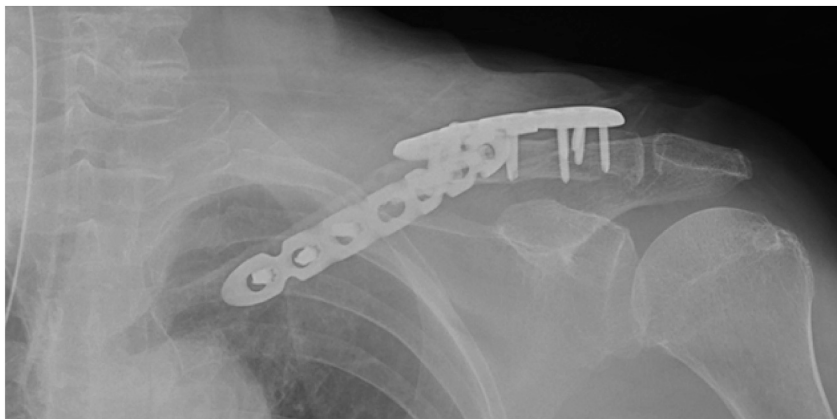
Postoperative X-ray of the bipolar clavicle fracture; the midshaft fracture was fixed with a VA-LCP anterior clavicle plate (DePuy Synthes) and the distal fracture was fixed with a superior anterior clavicle plate with lateral extension (DePuy Synthes).
